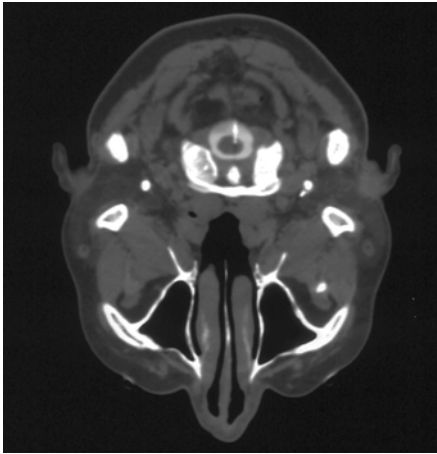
Final position of the electrode on axial CT scan at occiput-C1 level in TR-NC
